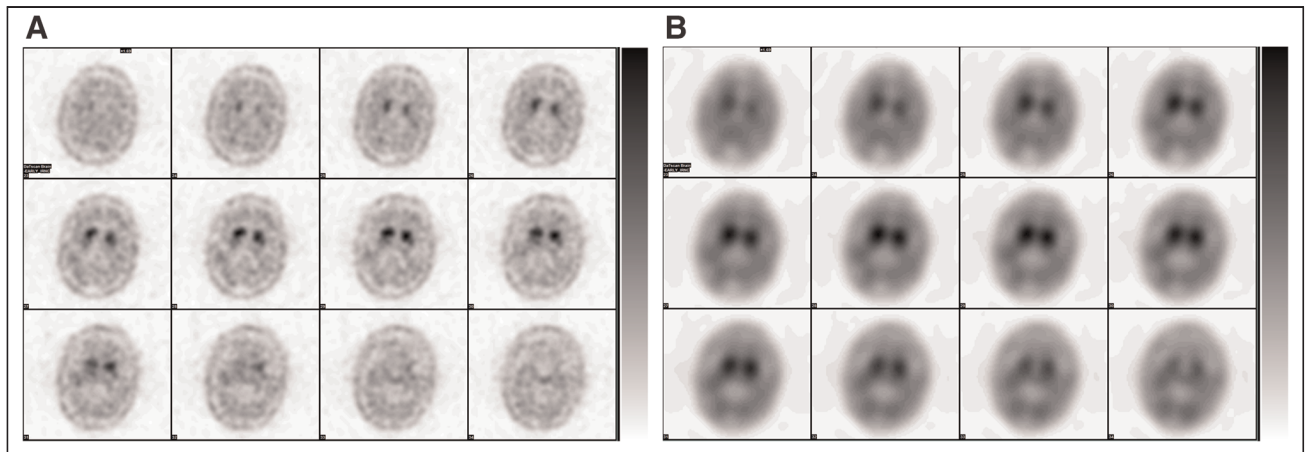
Axial brain SPECT images of 80-y-old man on carbidopa–levodopa without improvement of tremors, shuffling gait, and bradykinesia for 2–3 mo. (Left) Images showing decreased uptake bilaterally in putamen and loss of normal comma shape. These findings are scintigraphic evidence of presynaptic-deficit parkinsonian syndrome with probable age-associated changes due to no improvement with medication. (Right) Images showing oversmoothing artifact.
